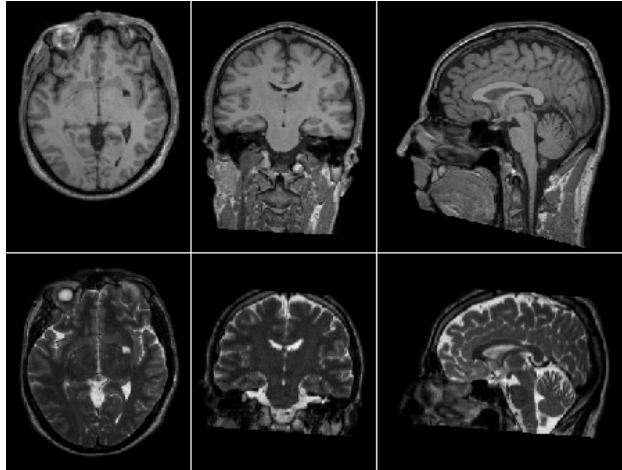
T1 weighted (top row) and T2 weighted (bottom row) magnetic resonance images of a human brain.
